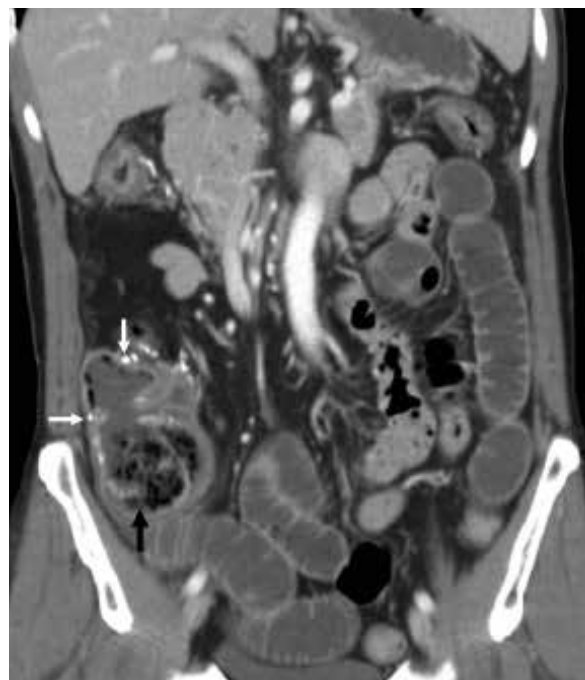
Enhanced CT reformation coronal image shows numerous serpiginous linear calcifications (white arrows) in the serosal surface of the colon wall and in the adjacent pericolic fat. There is a 4 cm fecal bezoar (black arrow) impacted in the cecum, with partial obstruction of the ileocecal valve, resulting in small-bowel dilatation. The surface of the liver is uneven, with nodularity, which proved to be cirrhosis of the liver.
